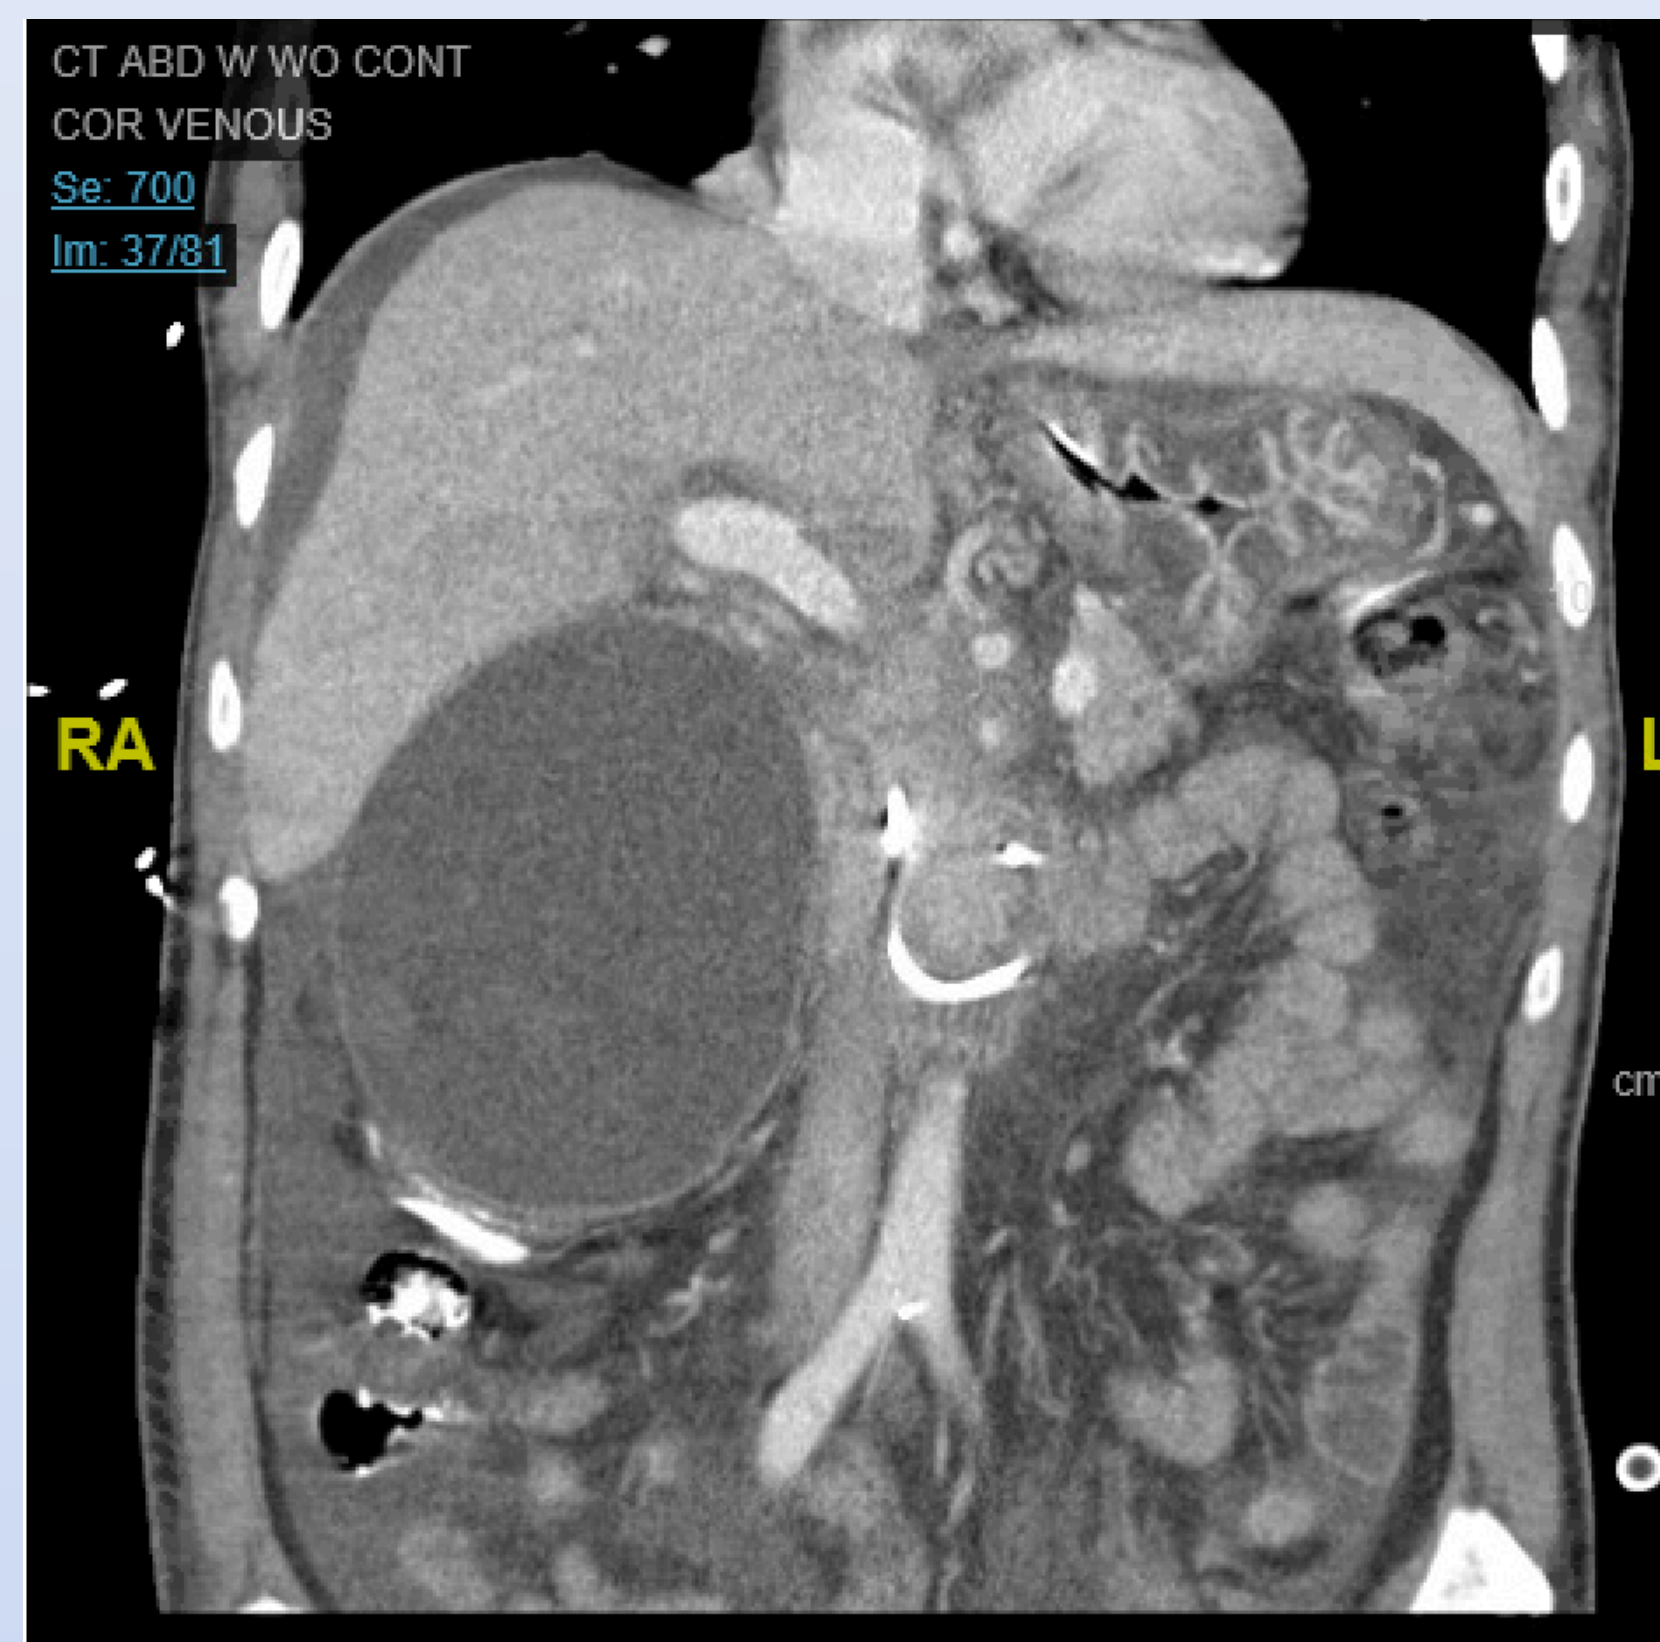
CT Abdomen (coronal)
